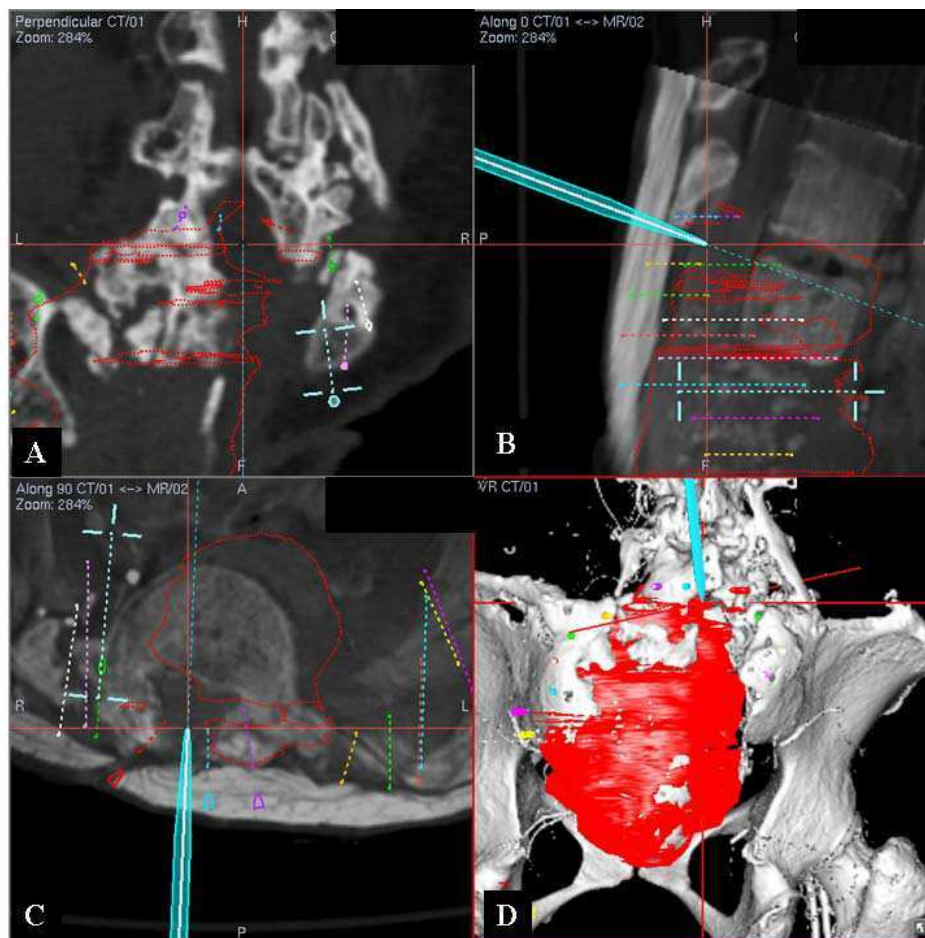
(A) Coronal section of CT image, (B) sagittal and (C) axial sections of CT/MR fused images, and (D) 3-D bone tumor model for Patient 12 with recurrent mesenchymal chondrosarcoma of sacrum are shown. The patient had two previous operations and posterolateral fusion between lower lumbar spines and iliac crest. The tip of navigation probe was pointing at the location where previous laminectomy was performed at L5 level. Intraoperative navigation helped surgeons to identify with confidence the structures and intended bone resections in patients with distorted anatomy from their tumors or previous operations
